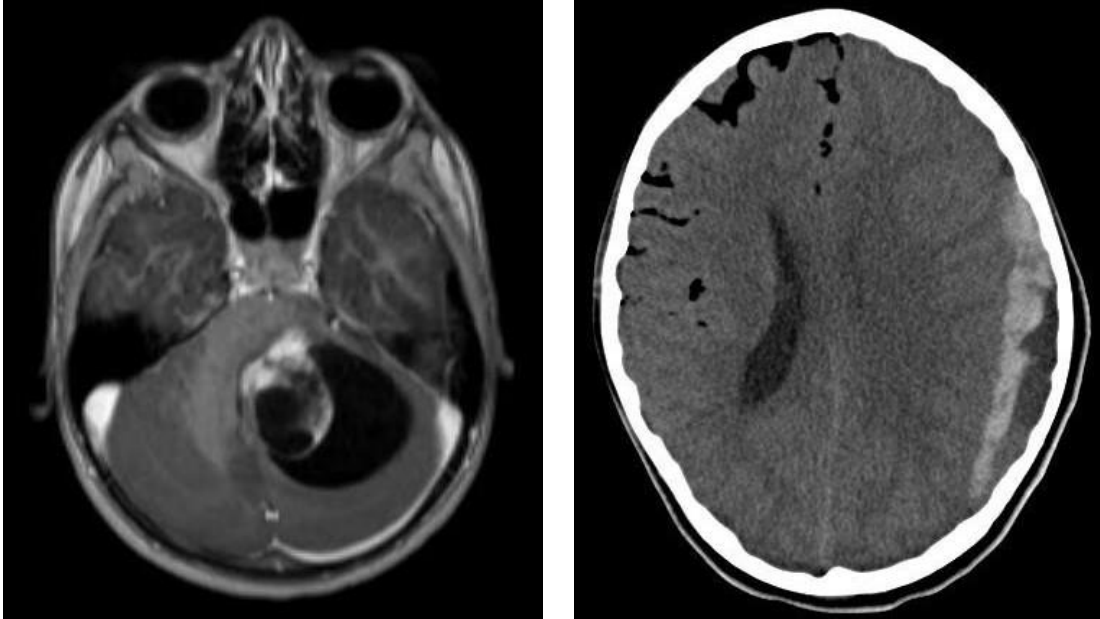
Post-operative CT-scan imaging showing a left hemispheric epidural haematoma with a small depressed skull fracture at the site of the single pin.
